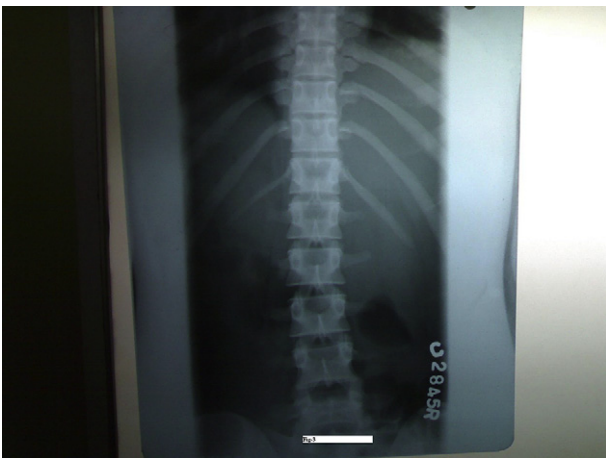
X-ray dorso-lumbar spine shows no abnormality.
